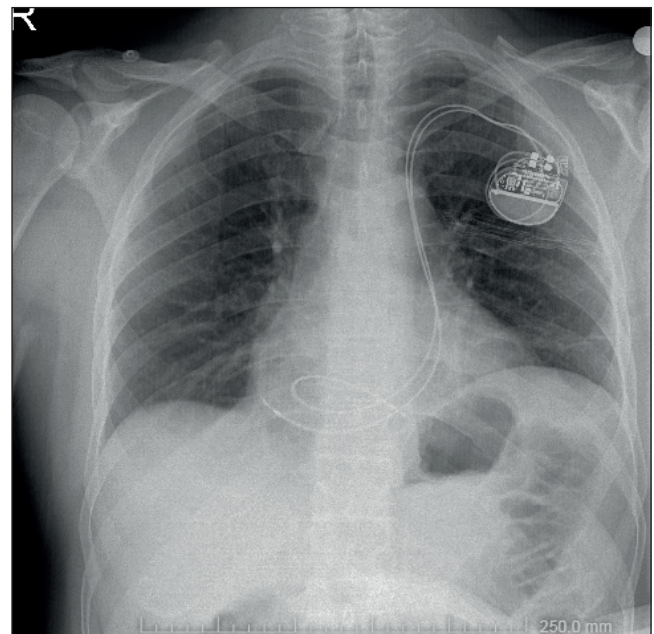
Radiographic view of the final placement of the right atrial and ventricular leads via persistent left superior vena cava and coronary sinus.
